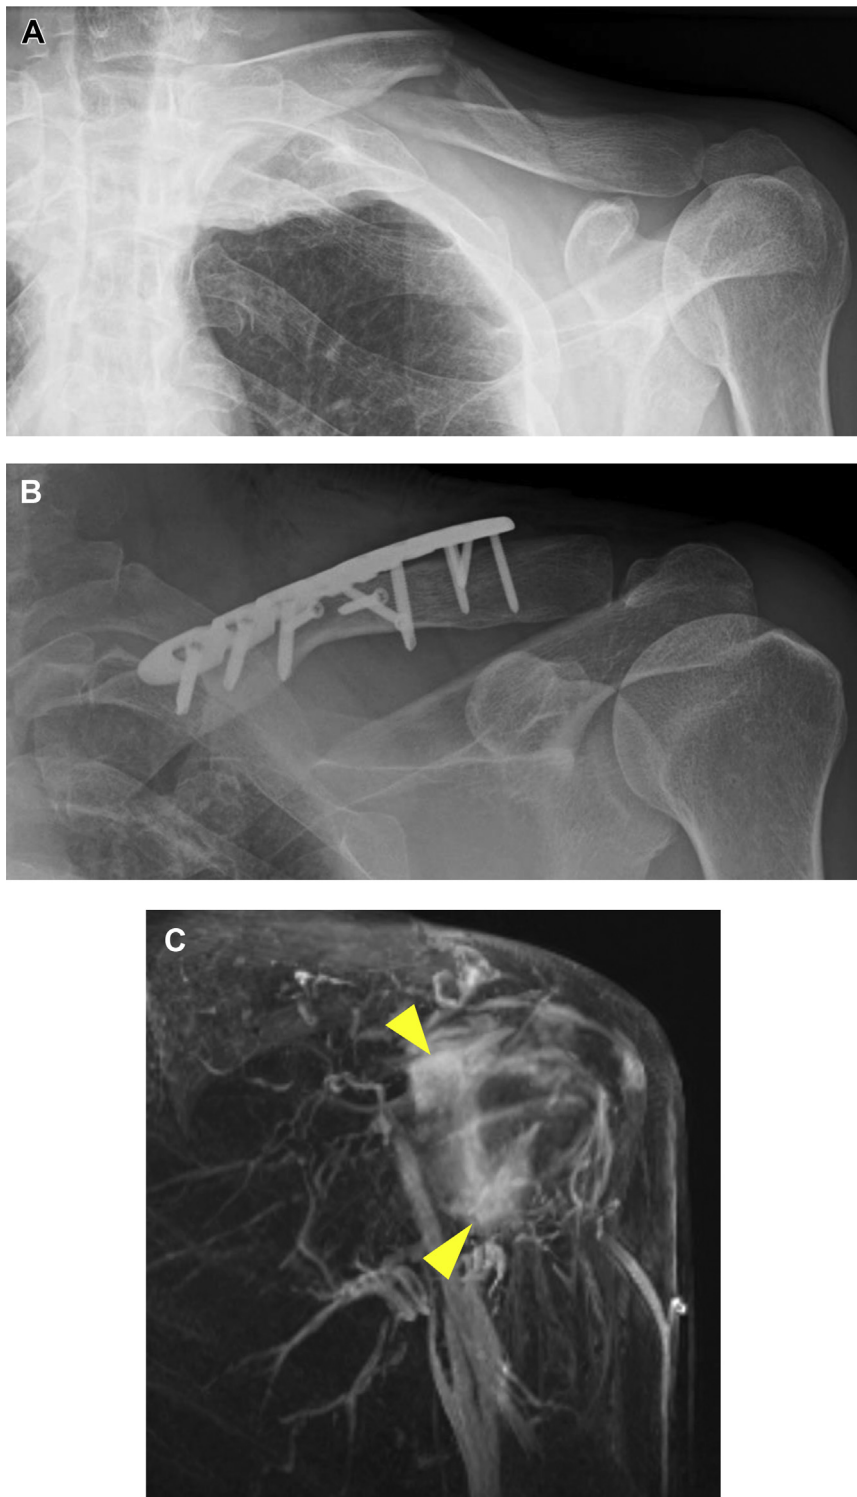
Case 1: A 57-year-old man with a left middle clavicle fracture. (A) Initial radiograph showing a displaced middle clavicle fracture. (B) Postoperative radiograph showing open reduction and internal fixation. (C) Dynamic magnetic resonance imaging findings at 153 s (late phase) show strong enhancement at the rotator interval and axillary pouch (arrowheads).
